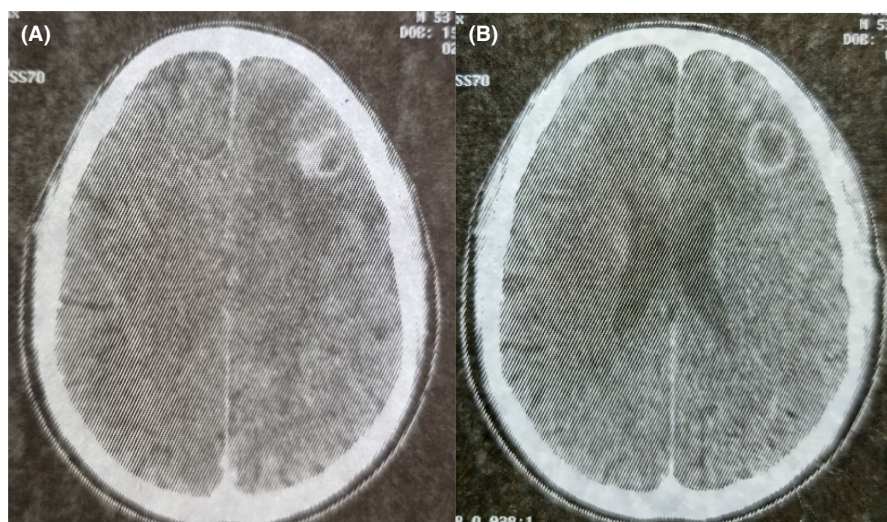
Cerebral computed tomography (axial section) (pretreatment) showed an intra-axial localized lesion in the left frontal tissue with cocardial enhancement surrounded by perilesional edema without mass effect.
